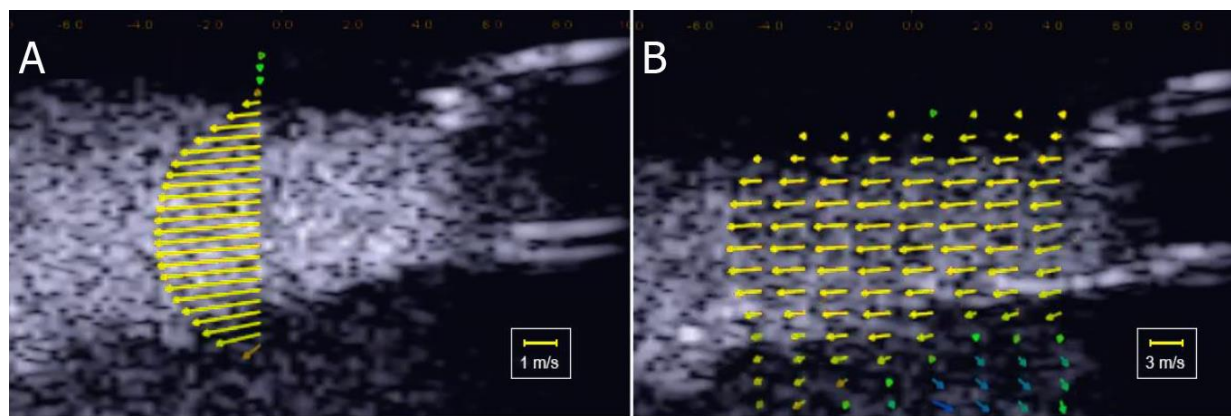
Screenshots from the ULA-OP 256 scanner while investigating with MLVD a 3 m/s jet produced by a syringe. A: Real-time MLVD at 1 line is superimposed on B-mode at PRF=16 kHz; B: VRT MLVD at 8 vector Doppler lines is superimposed on the B-mode and slowed down 5-fold.
